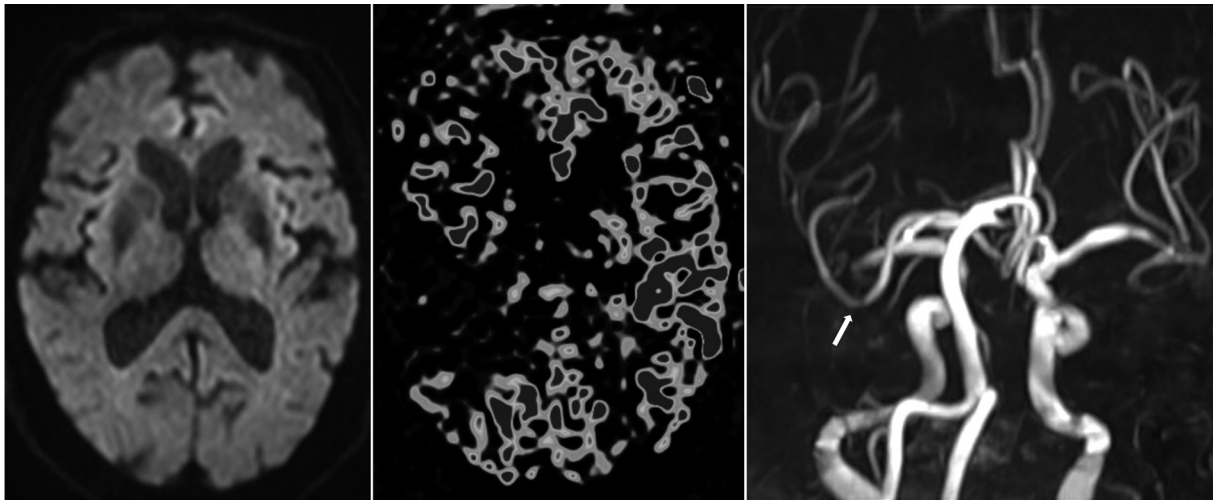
Magnetic resonance imaging (MRI) scan results at the stroke center after intravenous administration of recombinant tissue plasminogen activator at the first hospital. Left: Diffusion-weighted axial image. Middle: Arterial spin labeling imaging. Right: Magnetic resonance angiography. The MRI at the stroke center revealed a decrease in the cerebral blood flow in the right middle cerebral artery (MCA) territory; however, the right MCA had already recanalized (arrow) and there were no infarcted areas on diffusion-weighted imaging.
